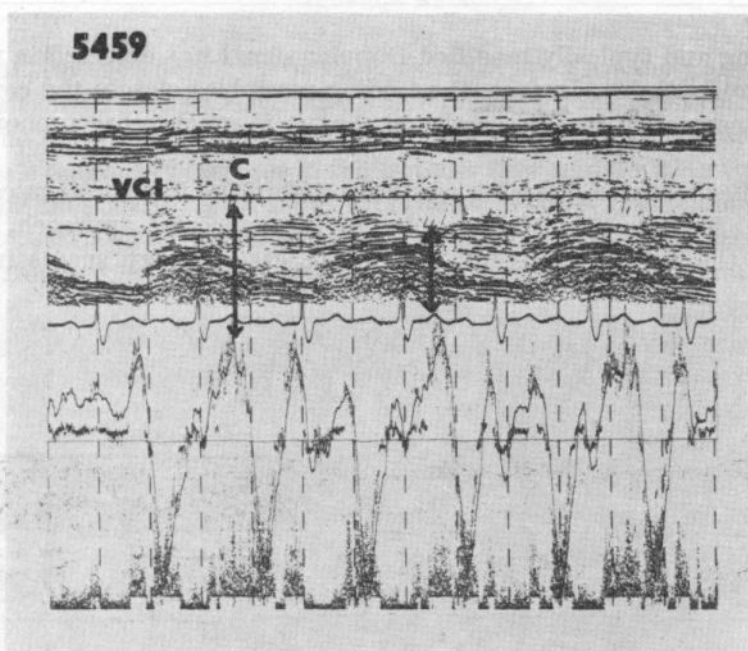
Tricuspid regurgitation. The diastolic-systolic turbulence pattern due to the regurgitant microbubbles into the inferior vena cava (VCI). The arrows indicate the moment of Doppler changes
